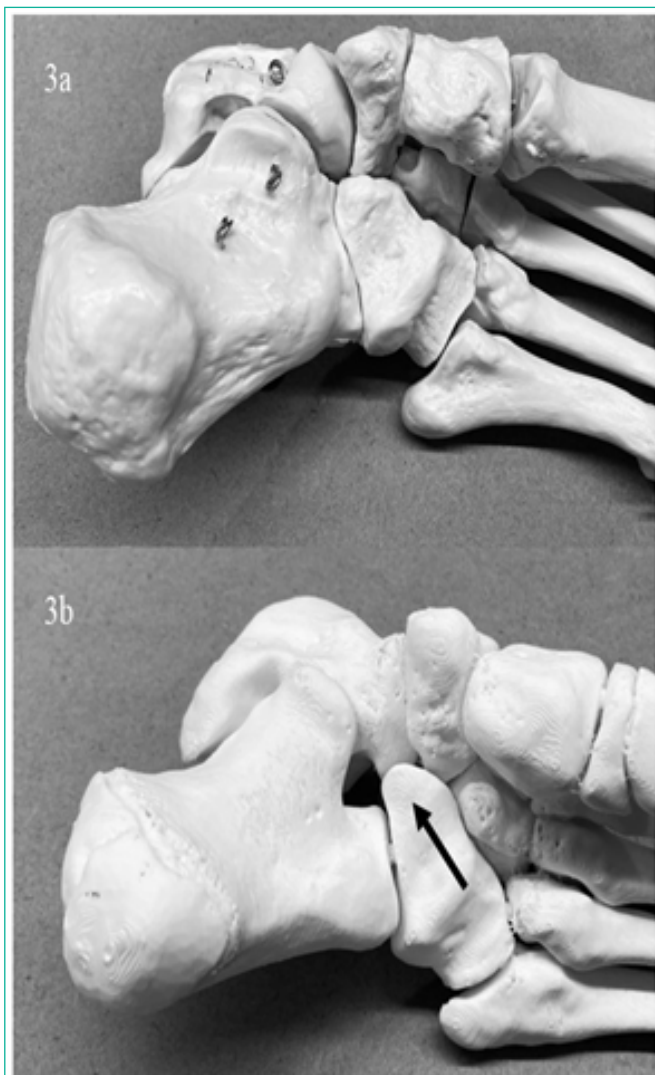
Inferomedial views of the printable 3D model created from a CT scanner of the left foot and of a normal normal skeletal foot. On the image 3a, the normal appearance of the calcaneonavicular space. On the figure 3b, we noted that the anterior calcaneus process was absent, and that the too-large medial process of the cuboid (arrow) occupied the calcaneonavicular space where it behaved like a real coalition. In addition, there was a real joint between the abnormal medial process of the cuboid and the talus.
